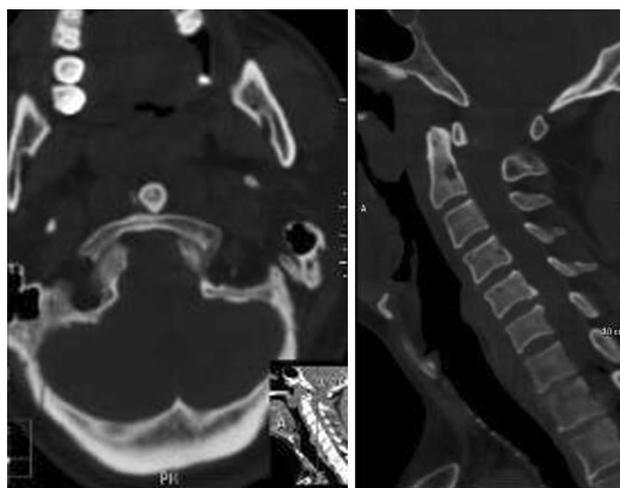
Axial CT scans confirmed that the odontoid peg was ventral to the anterior arch of the atlas (a). Sagittal reconstructions verified lack of rotation or fractures of the odontoid
